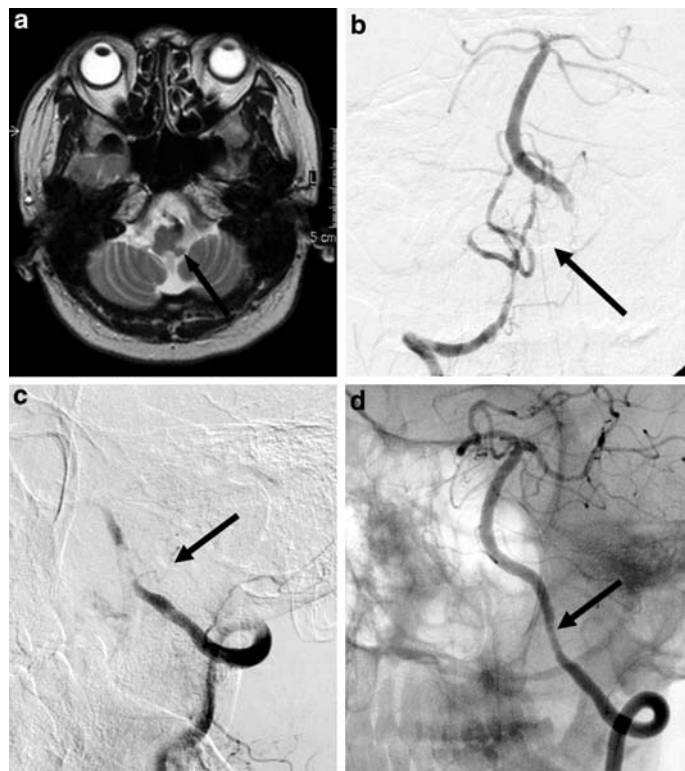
(a) MRI T2WI on admission revealed infarction of the left lateral medulla (*arrow*). (b) and (c) DSA showed diffuse stenosis of the right vertebral artery (b; *arrow*) and severe tapered stenosis of the left vertebral artery (c; *arrow*). (d) left vertebral DSA showed that the stenotic lesion was well dilated after stent placement (d; *arrow*)
